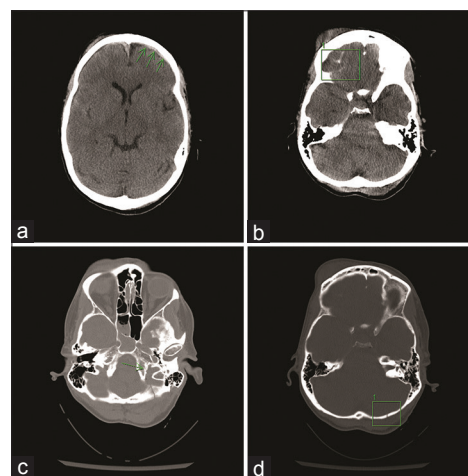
Acute injury CT exam (a-d): (a) Axial frontal subdural hematoma left (b) axial frontal subdural hematoma (c) occipital fracture 1 (d) occipital fracture 2
